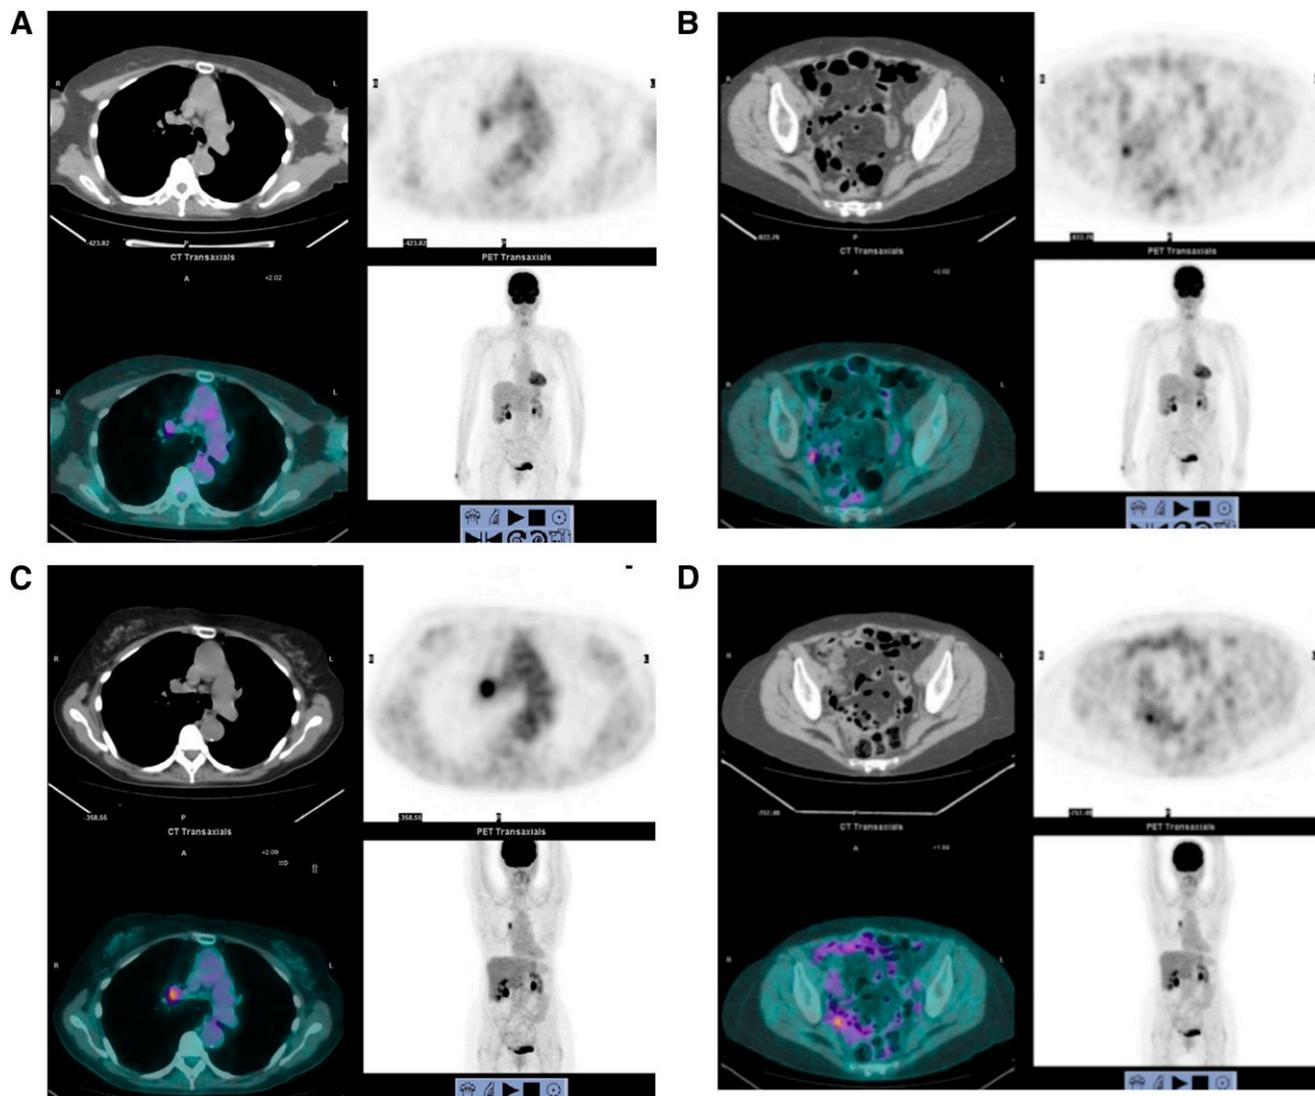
A 68-y-old woman presented with rising CA-125 levels and normal findings on CT. (A and B) At restaging, transaxial PET/CT slice through chest (A) demonstrates moderate (same as blood pool) ^{18}F -FDG uptake in right hilum, corresponding to 1.6-cm lymph node, consistent with metastasis; transaxial PET/CT slice through focus of ^{18}F -FDG uptake in right lower quadrant (B) demonstrates moderate ^{18}F -FDG uptake in 0.5-cm right serosal implant, consistent with metastasis. This lesion was identified on CT retrospectively because of ^{18}F -FDG uptake. (C and D) Three months after chemotherapy, transaxial PET/CT slice through chest (C) demonstrates more intense (greater than blood pool) ^{18}F -FDG uptake in right hilar lymph node and slight increase in size, consistent with progressive disease; transaxial PET/CT slice through pelvis (D) demonstrates more intense ^{18}F -FDG uptake in right serosal implant, consistent with progressive disease.
